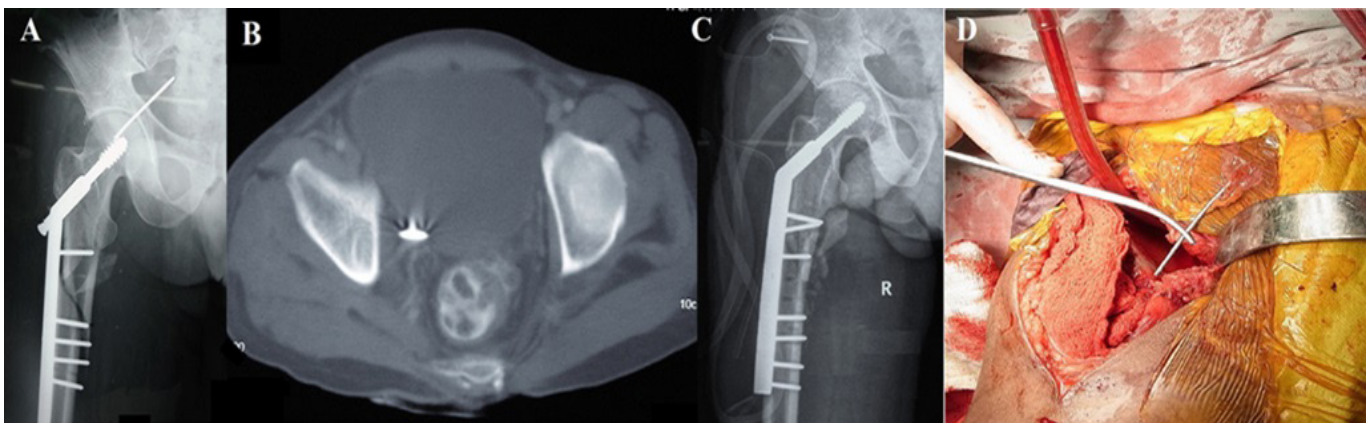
(A) Antero-posterior radiograph of hip and proximal femur showing broken transfixing guidewire (B) Computed tomography scan of pelvis axial section showing guidewire tip exiting from quadrilateral plate (C) Postoperative radiograph of hip and proximal femur after removal of guidewire from hip joint showing iliac bone osteotomy fixed with screw (D) Intra operative clinical photograph of the surgical site showing the exposure with broken guidewire.
